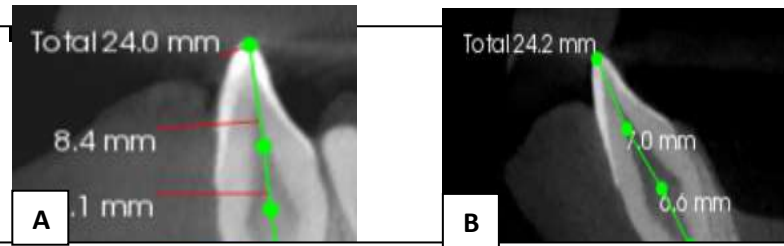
(A) Pre-treatment and (B) Post-retraction CBCT of patient treated with Geometry-X
